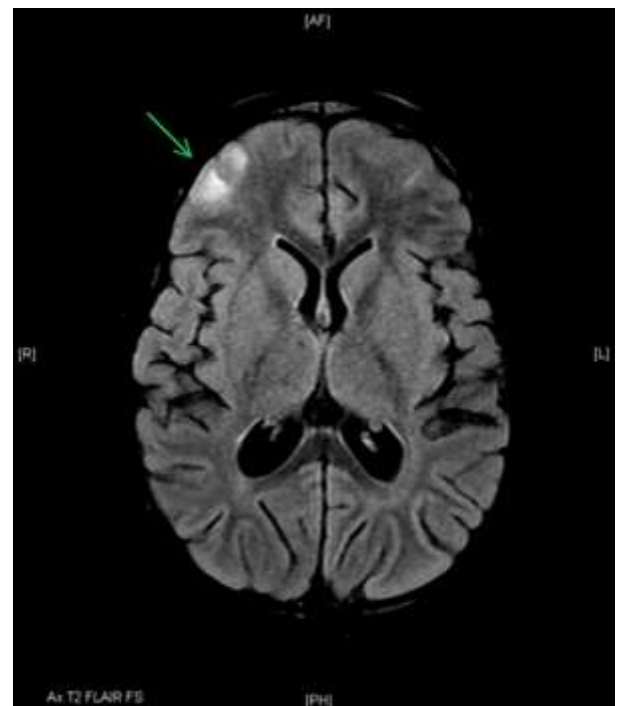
Axial T2 FLAIR imaging revealing foci of increased signal intensity in right frontal subcortical white matter that resolved after chemotherapy
